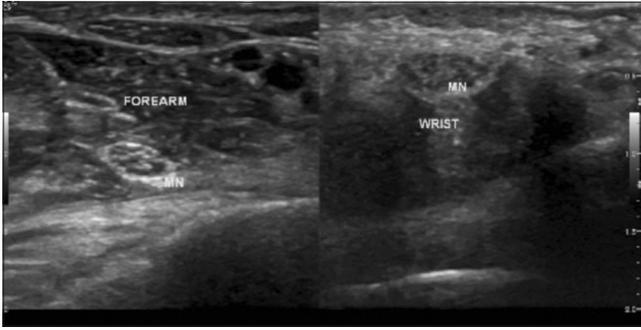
Ultrasound image of forearm and wrist.
